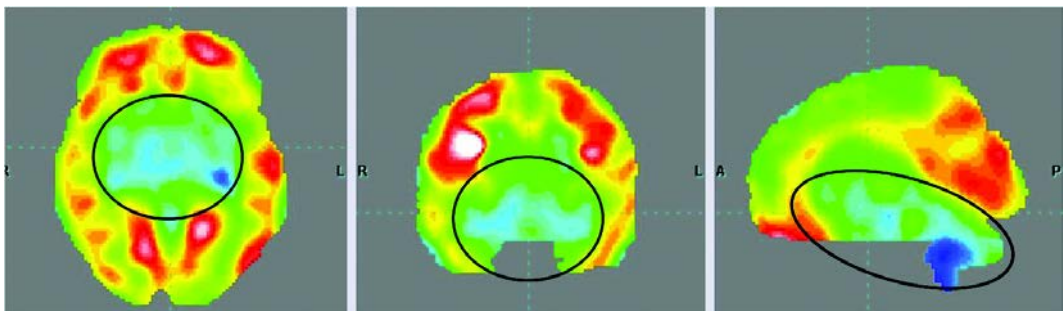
PET-CT scan after stem cell therapy showing increased metabolic activity in bilateral cerebellar lobes and thalami bilaterally
